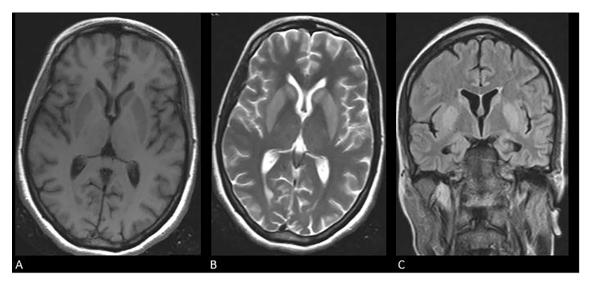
Axial T1 MRI showing Bipallidal hypointense lesion (A); axial T2 sequence showing hyperintense lesion in bilateral basal ganglia region (B); and coronal FLAIR showing hyperintense Bipallidal lesion (C).
